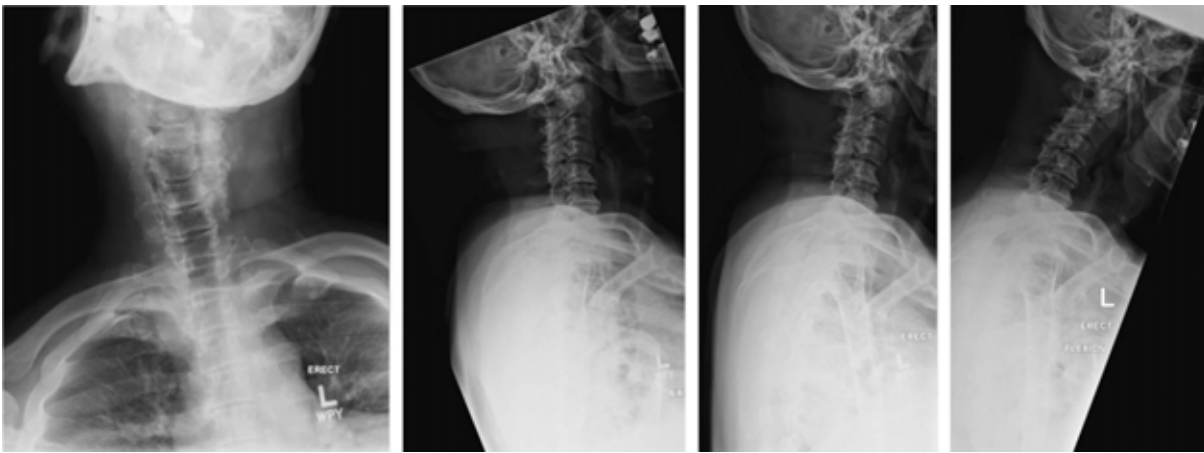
AP and lateral radiographs demonstrating head roll to the left associated with multi-level left-sided spondylosis. No instability is observed on flexion/extension views.
